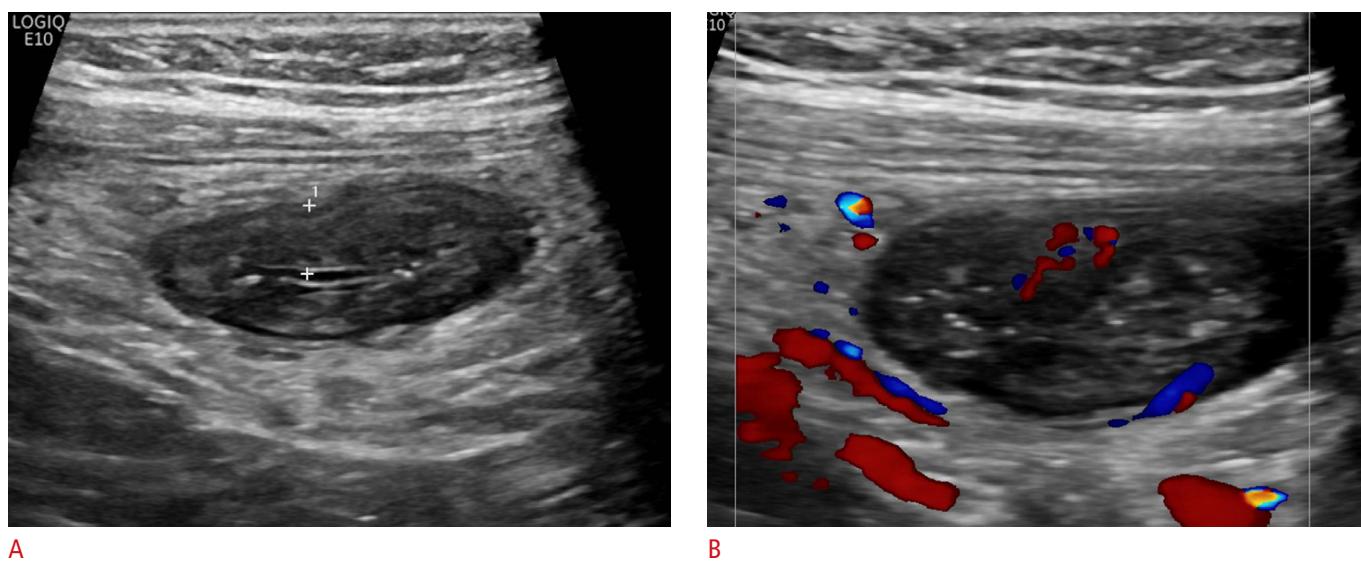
Ultrasonographic parameters of active inflammation.
